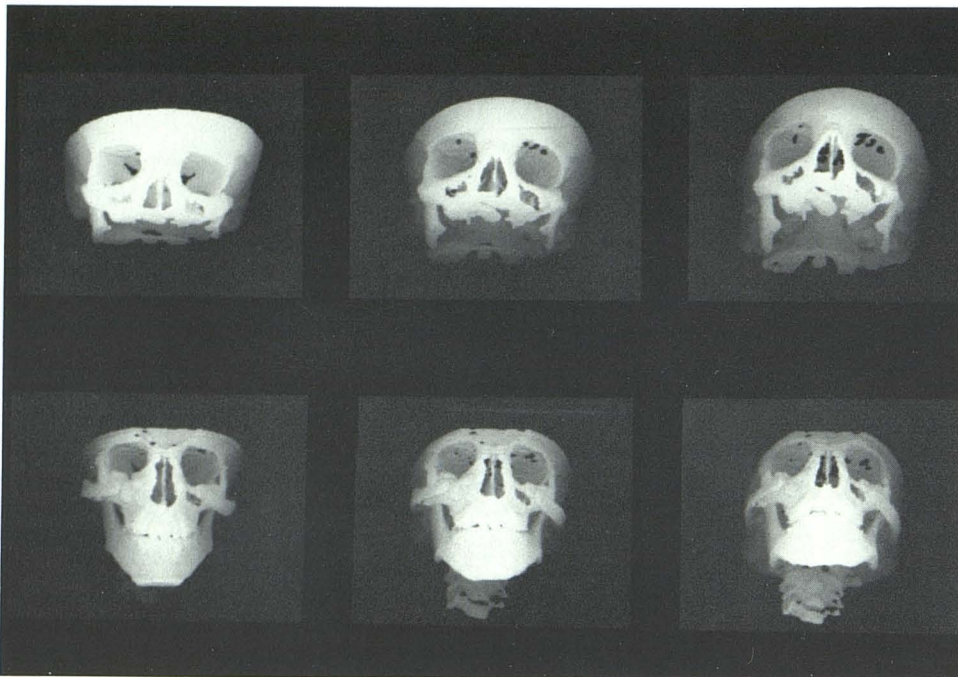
Case 7. Treacher-Collins syndrome. 3-D CT reformation about X axis shows preoperative asymmetry (top) of sides. Left side shows marked hypoplasia of frontal process of frontal bone and zygoma, seen to lesser degree on right. Zygomatic arches are not developed bilaterally. On postoperative examination (bottom), bone grafts form zygomatic arches. Asymmetry is noted as left is angulated inferiorly. Overlay bone grafts along lateral orbital walls.
